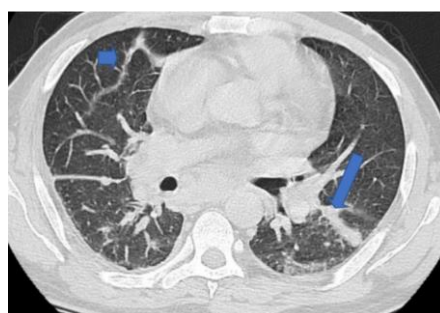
Axial parenchymal window CT section, showing bands of atelectasis in the middle lobe and dorsal segment of the left lower lobe with associated septal and nonseptal thickening
